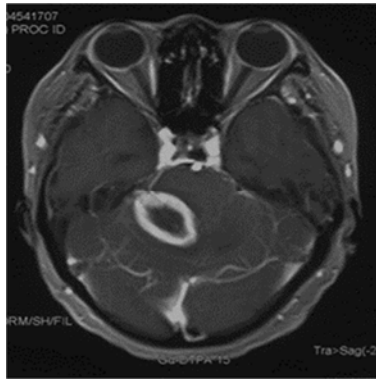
Repeated MRI 11 days later revealed a fast-growing tumor.
